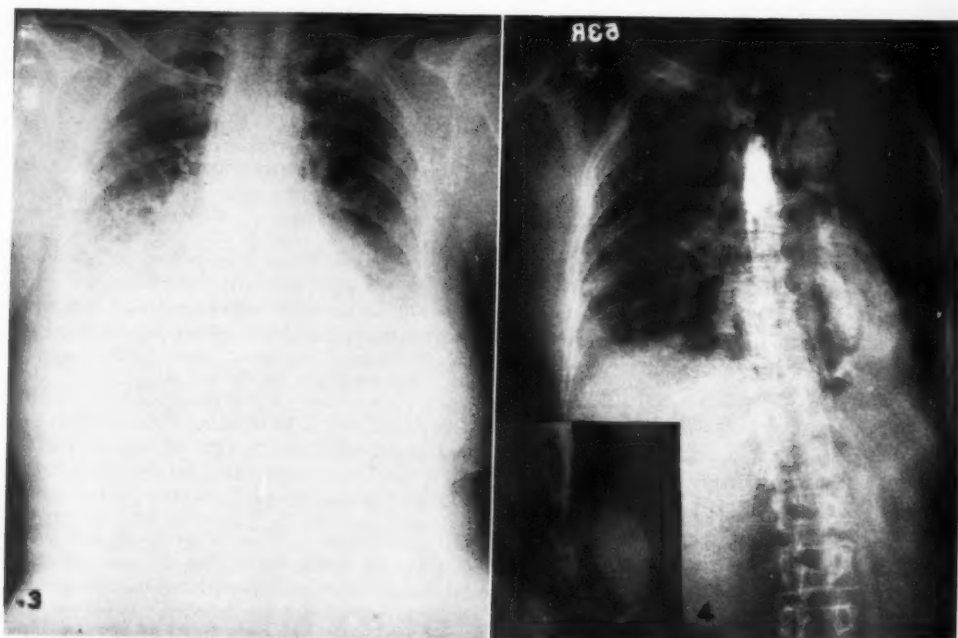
Case II. Roentgenogram of chest showing bilateral parenchymal infiltrates right hydrothorax, pneumomediastinum, and subcutaneous emphysema.
